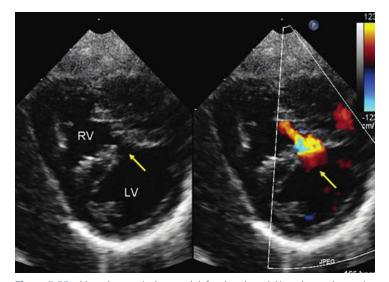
Muscular ventricular septal defect (moderate). Note the moderate-size defect (*arrow*) in the muscular septum on the parasternal short axis view (*left*). Color Doppler image (*right*) shows left-to-right shunt (*arrow*). LV, left ventricle; RV, right ventricle.
